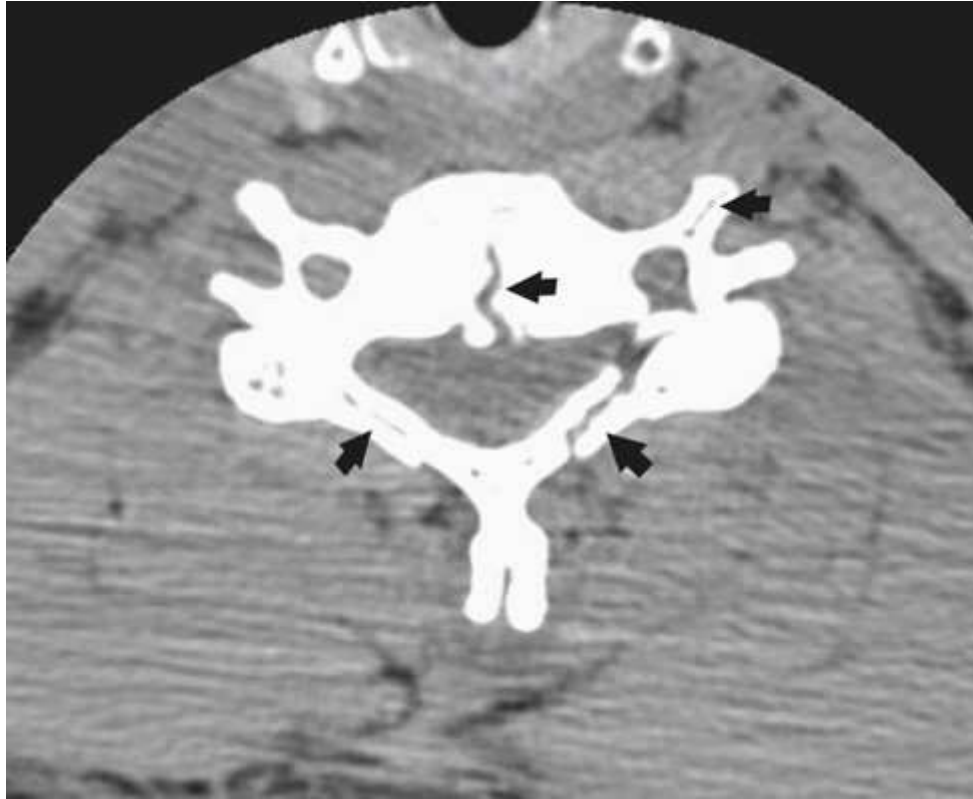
CT scan of C5 showing multiple fractures (*arrows*) resulting from a fall from a tree. Courtesy Sunie Grossman, RT[R], St. Bernard's Medical Center, Jonesboro, AR.
